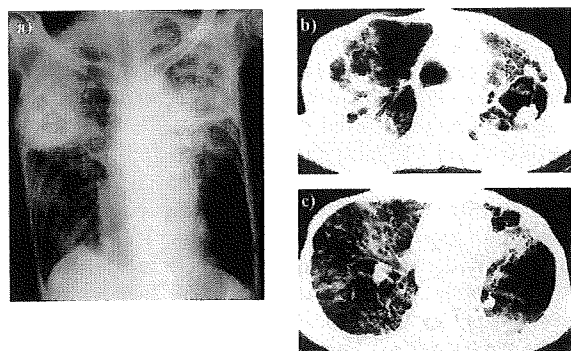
(a) Chest radiograph revealed a cavitory lesion in the left upper lung field and infiltrative shadow in the right upper and middle lung fields (Case 2). (b), (c) Chest CT showed a fungus ball in the cavity in the left upper lobe and consolidation in the right upper and middle lobes (Case 2).
